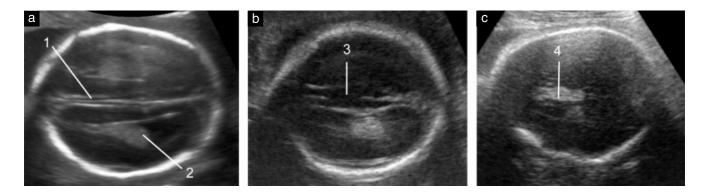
(a-c) Summary of sonographic findings that are associated with agenesis of the corpus callosum in the axial plane: 1) the cavum septi pellucidi (CSP) is not demonstrated and its position is occupied by three lines that are due to the widened interhemispheric fissure, centrally partitioned by the falx cerebri; 2) the frontal horns of the lateral ventricles are further away than normal from the midline (laterally displaced) and the atria of the lateral ventricles slightly enlarged; this results in a 'tear-shaped' appearance of the lateral ventricles; 3) an interhemispheric cyst is seen; 4) an echogenic structure is seen in the position normally occupied by the CSP; this is a lipoma, which is frequently associated with partial or complete callosal agenesis but is usually visible only in late gestation.
